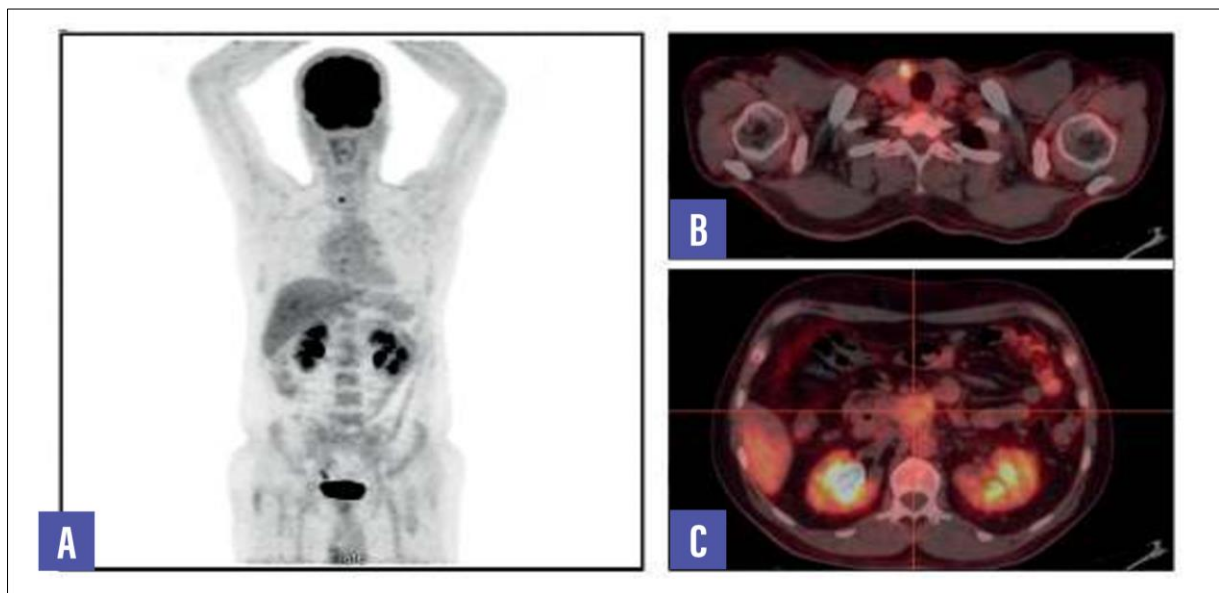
18F-FDG PET/CT findings. Maximum intensity projection image showing the whole-body acquisition (A), a right thyroid hypermetabolic focus (B), and very mild hypermetabolism within the retroperitoneal lesion area (C)
